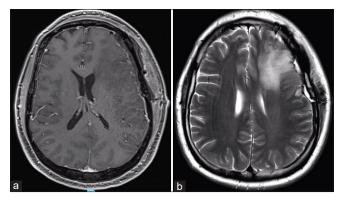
Magnetic resonance imaging at the post operated showed total resection of the left frontal tumor associated with edema, determining deletion of the local cortical grooves, compression of the frontal horn of the left lateral ventricle and contralateral midline deviation. (a) Axial gadolinium-enhanced image. (b) Axial T2-weighted.
